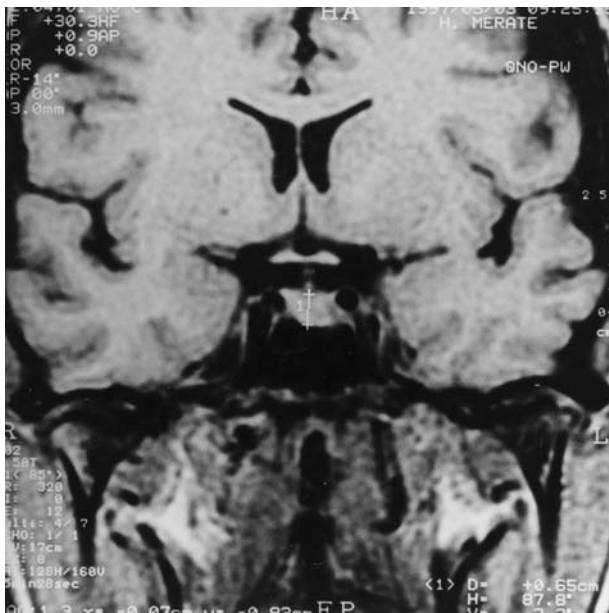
Case I: Coronal section of a T1-weighted magnetic resonance image showing a dense pituitary microadenoma after 12 months of cabergoline therapy.
